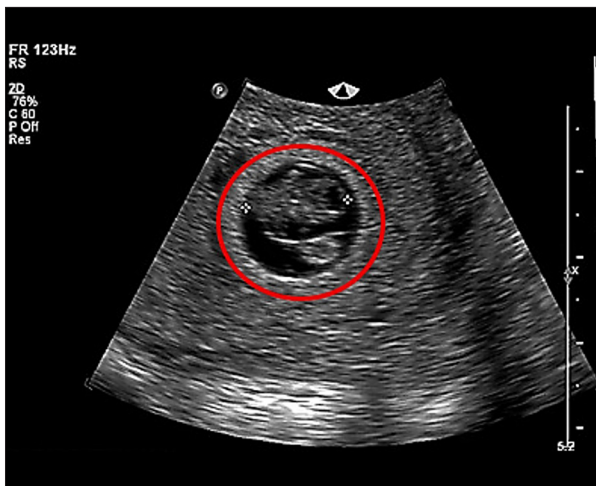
First-trimester diagnostic transvaginal ultrasound confirming structural parameters. The ultrasound demonstrates a restricted gestational sac accompanied by a severe presentation of oligohydramnios (highly deficient amniotic fluid volume).
